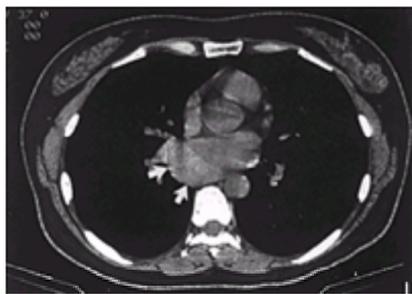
Chest computed tomographic scan showing mediastinal bronchogenic cyst (*arrows*) posterior and inferior to the carina.
